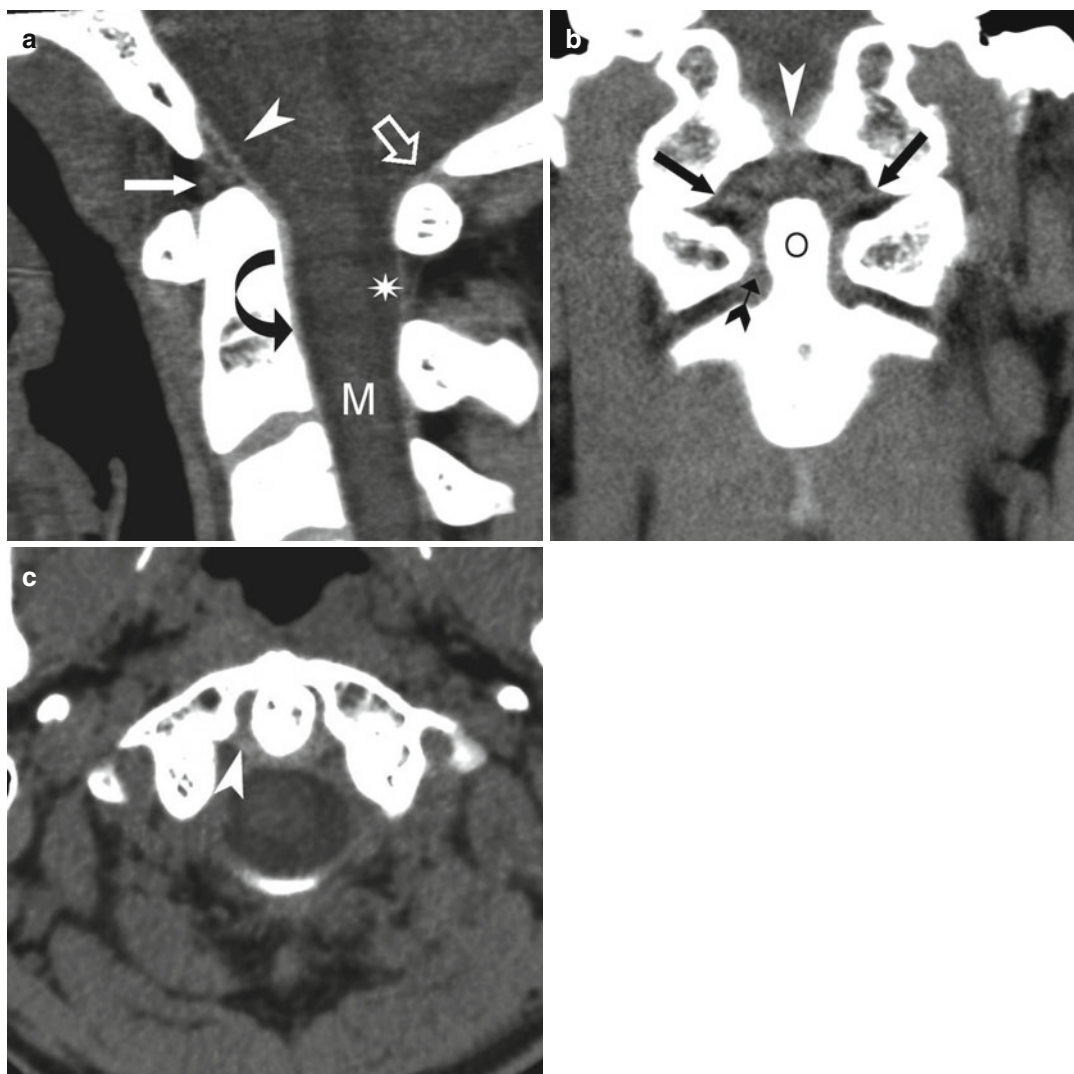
CT sagittal (a), coronal (b), and axial (c) reconstruction, with algorithm for soft parts, showing the main ligaments of occipito-cervical junction. (a) The tectorial membrane (*arrowhead*), cranial part of the posterior longitudinal ligament (*curved arrow*), apical ligament (*arrow*), and atlantooccipital membrane (*empty arrow*).
